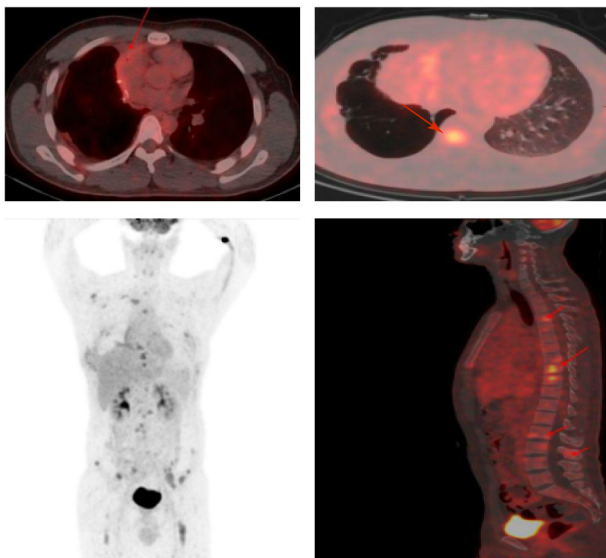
The PET/CT examination revealed a metabolic increase in the surgical area following mediastinal tumor surgery likely due to inflammation or tumor invasion. Red arrows indicate multiple areas of increased bone metabolism throughout the body, suggesting the possibility of distant metastasis. PET/CT, positron emission tomography/computed tomography.
